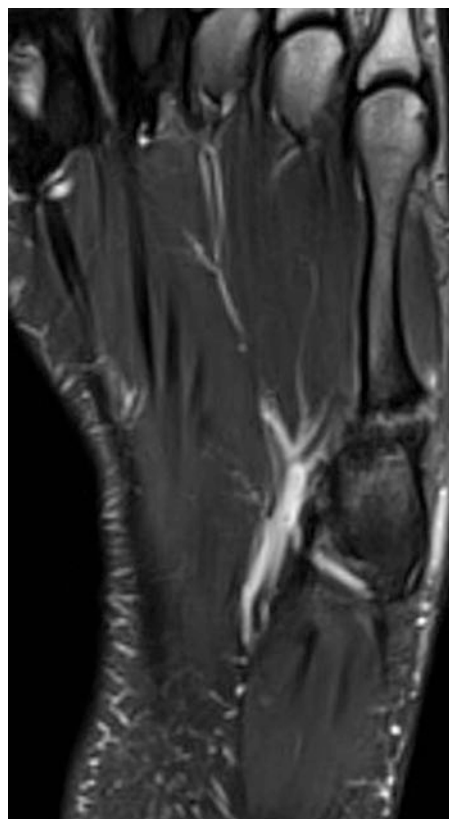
T1 weighted MRI (Transverse Plane) showing same nonunited Jones Fracture
